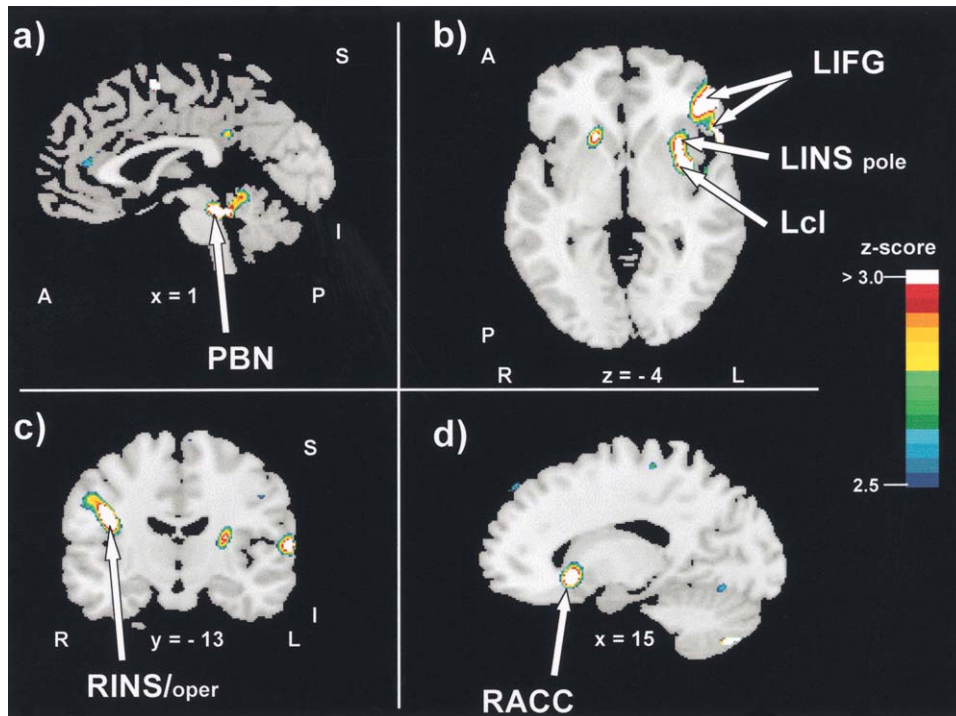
Increases in regional cerebral blood flow (rCBF) during stomach distention. Brain activity was estimated with PET using ^{15}O -water in 18 healthy young women during gastric balloon inflation and deflation. Difference images (inflation minus deflation) are superimposed on a single structural magnetic resonance image (gray scale brain areas). Colored areas are coded to represent the magnitude of change in rCBF as z-scores. Letters and numbers below the slices indicate their orientation and stereotactic coordinates.¹⁹ Arrows point to areas with significant changes in rCBF in four a priori defined regions of interest involved in visceral sensation: (a) dorsal brain stem nuclei; (b) left inferior frontal gyrus; (b and c) insular cortex/claustrium; (d) subgenual anterior cingulate cortex. A = anterior; I = inferior; L = left; Lcl = left claustrum; LIFG = left inferior frontal gyrus; LINS = left insula; LINS pole = left insular pole; P = posterior; PBN = parabrachial nucleus; R = right; RACC = right anterior cingulate cortex; RINS/oper = right insula/operculum; S = superior; x = sagittal plane; y = coronal plane; z = horizontal plane.
